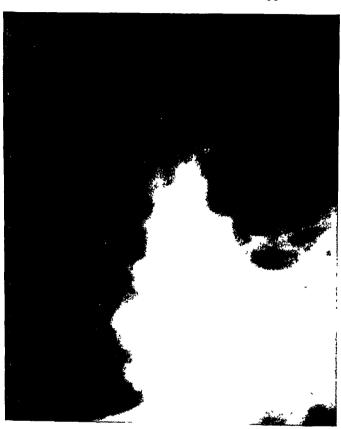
X-ray showing condition of chest in summer of 1928, eleven months after operation. The diaphragm on the left is seen to be intact. Beneath it is a gas bubble in the colon. Above, the lung is seen to be partially expanded, but does not extend out to chest wall. A comparison of the size of the right and left sides of the diaphragm, in this picture, shows the advantage gained by performing the preliminary extrapleural thoracoplasty.
